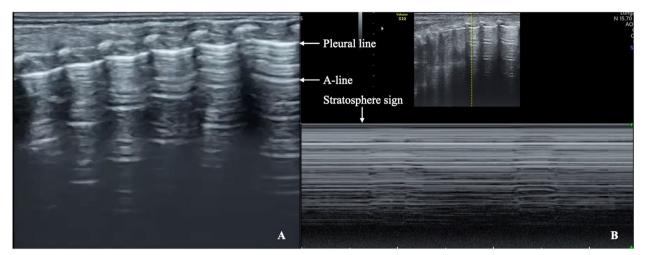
MV is often used for severe pneumothorax. LUS showed clear presence of pleural line and A-line on B-mode image (A) and a stratospheric sign on M-mode (B), lung sliding disappeared under real-time ultrasound scanning, while there are no spared area and lung point in the entire lung field. Which was consistent with the ultrasound imaging characteristics of severe pneumothorax. In most cases, the infants with severe pneumothorax need for invasive high-frequency oscillatory ventilation treatment
